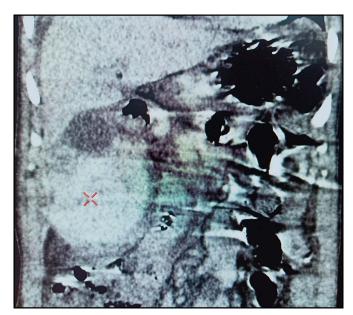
Noncontrast computed tomography scan, coronal view, showing a mass lesion probably arising from the liver and occupying the right subhepatic space with active hemorrhage.
